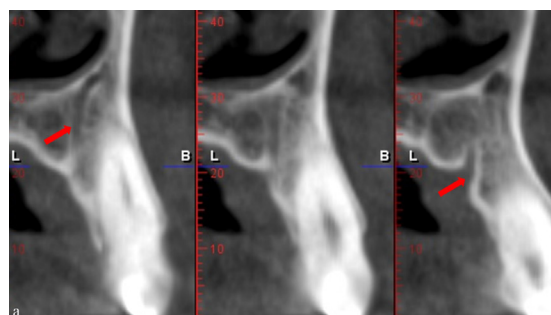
Cropped CBCT (cone-beam computed tomography) images of different patients showing the course of AC (accessory canal)
